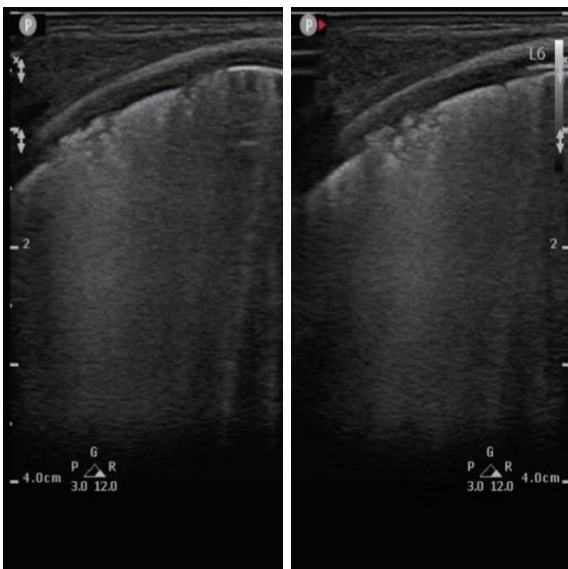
“Debris” lung ultrasound findings in BPD patients. BPD, bronchopulmonary dysplasia.
